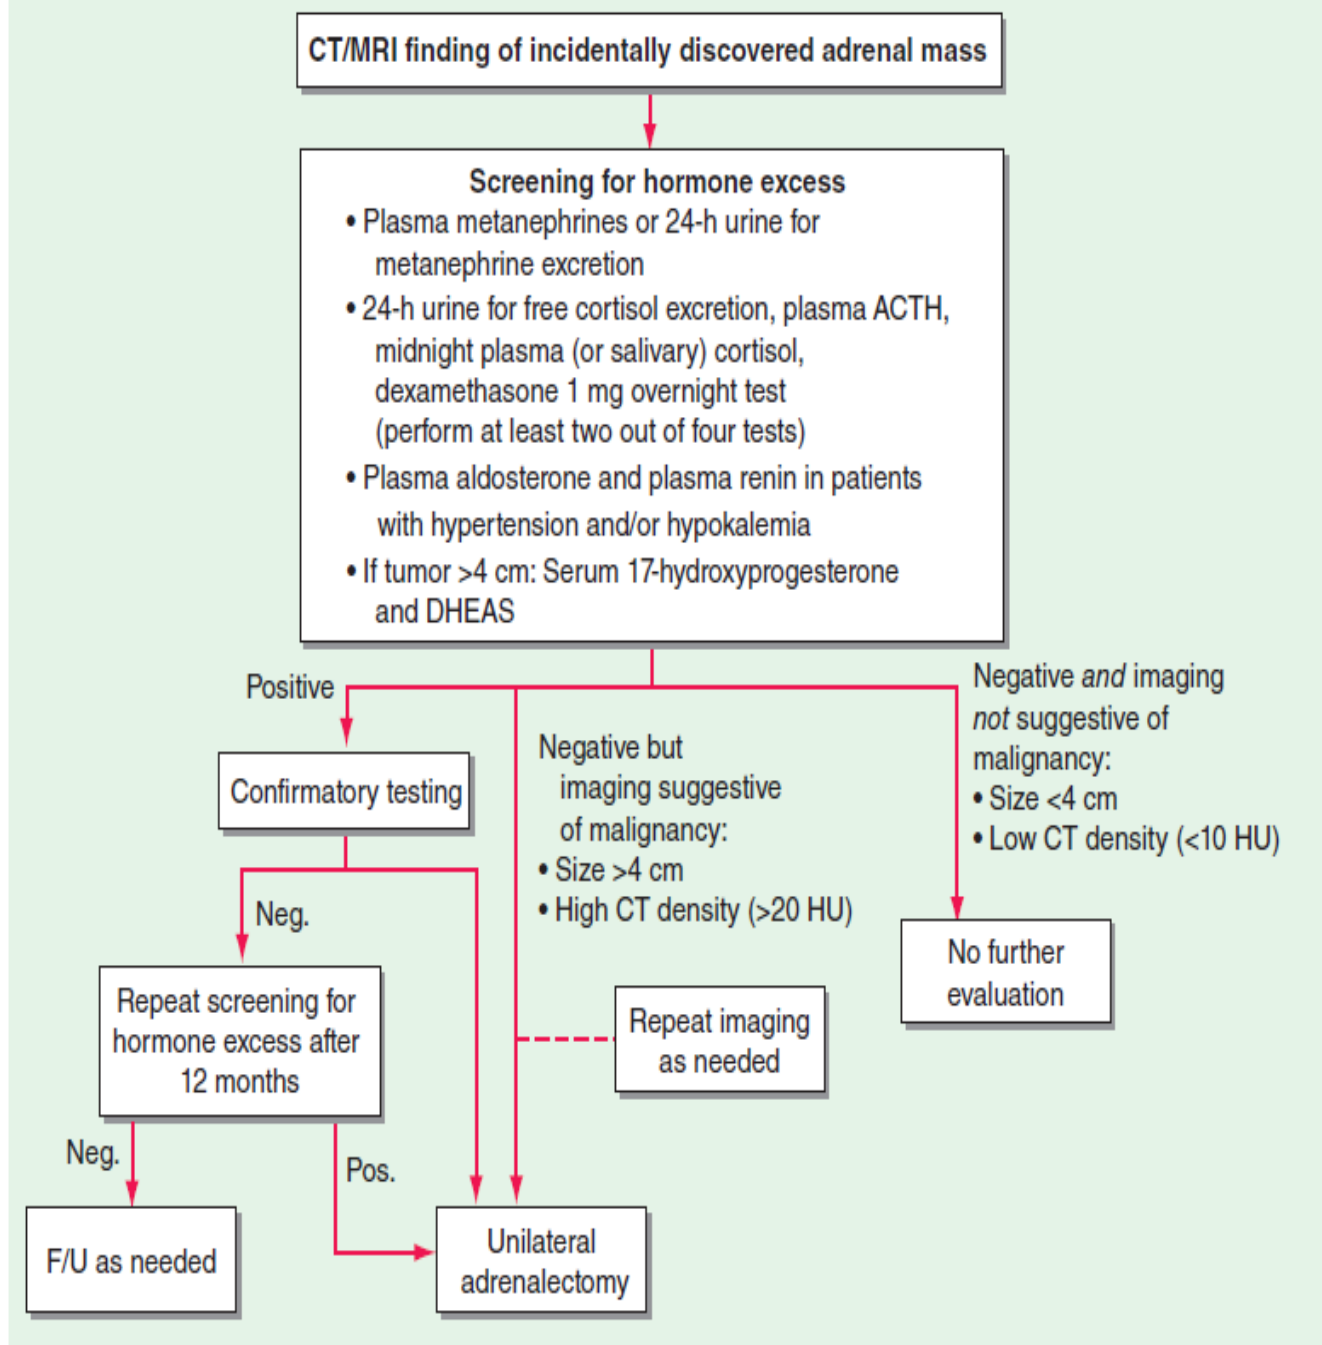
Management of the patient with an incidentally discovered adrenal mass. CT, computed tomography; F/U, follow-up; MRI, magnetic resonance imaging.
